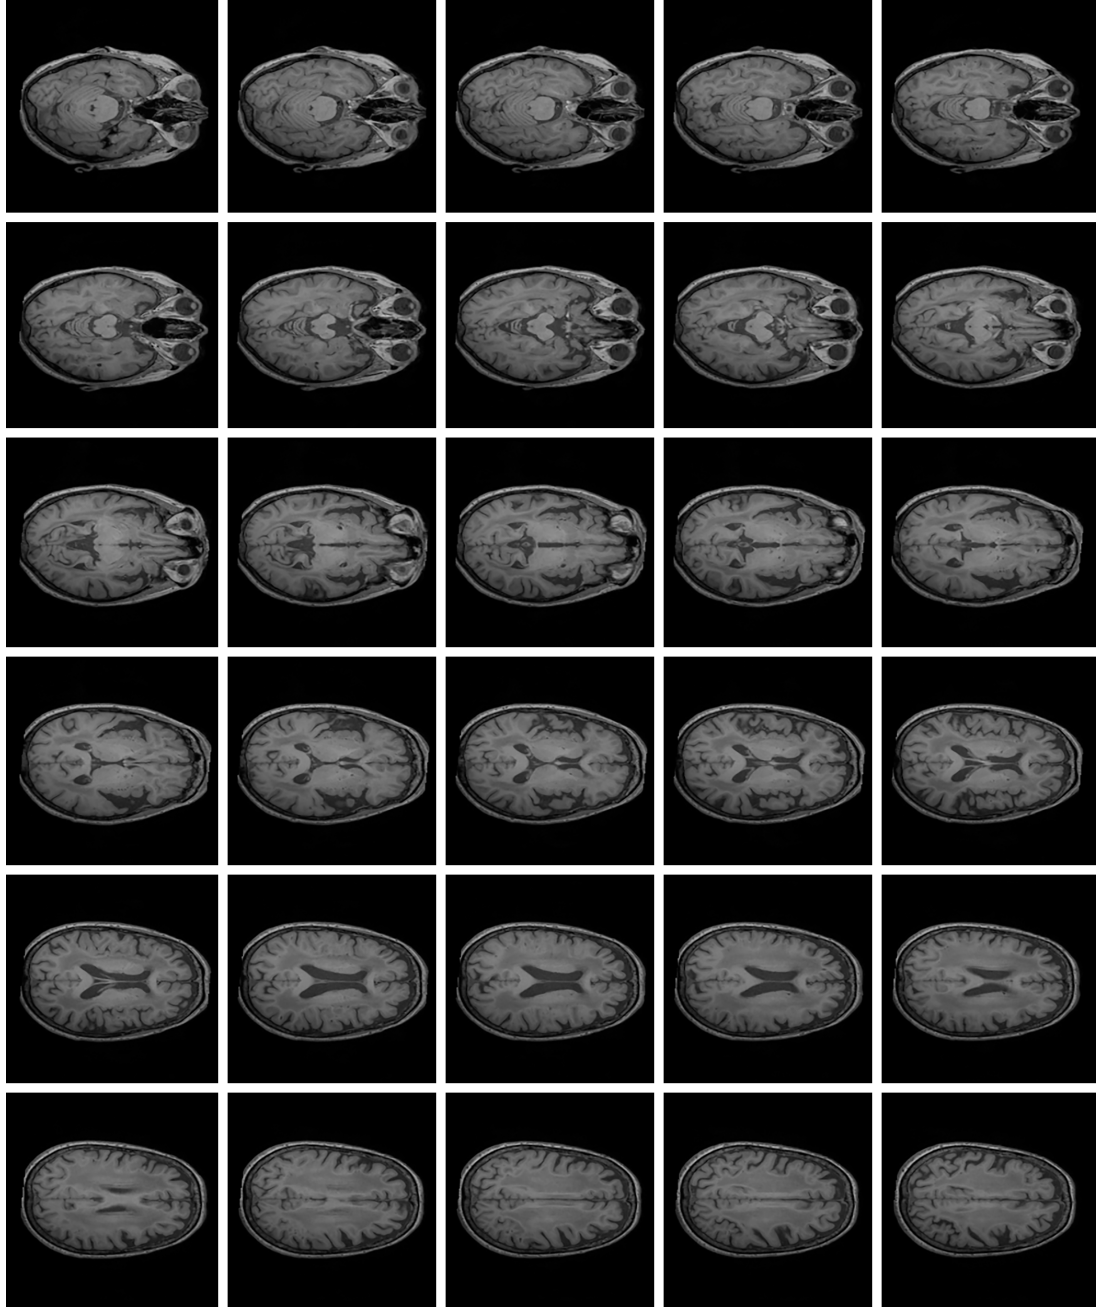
Slices of MRI volume of patient 0033A, diagnosed with multi-domain amnesic mild cognitive impairment. MRI volume considered for the experiments consists of 60 slices, out of which every other slice is shown in this figure
